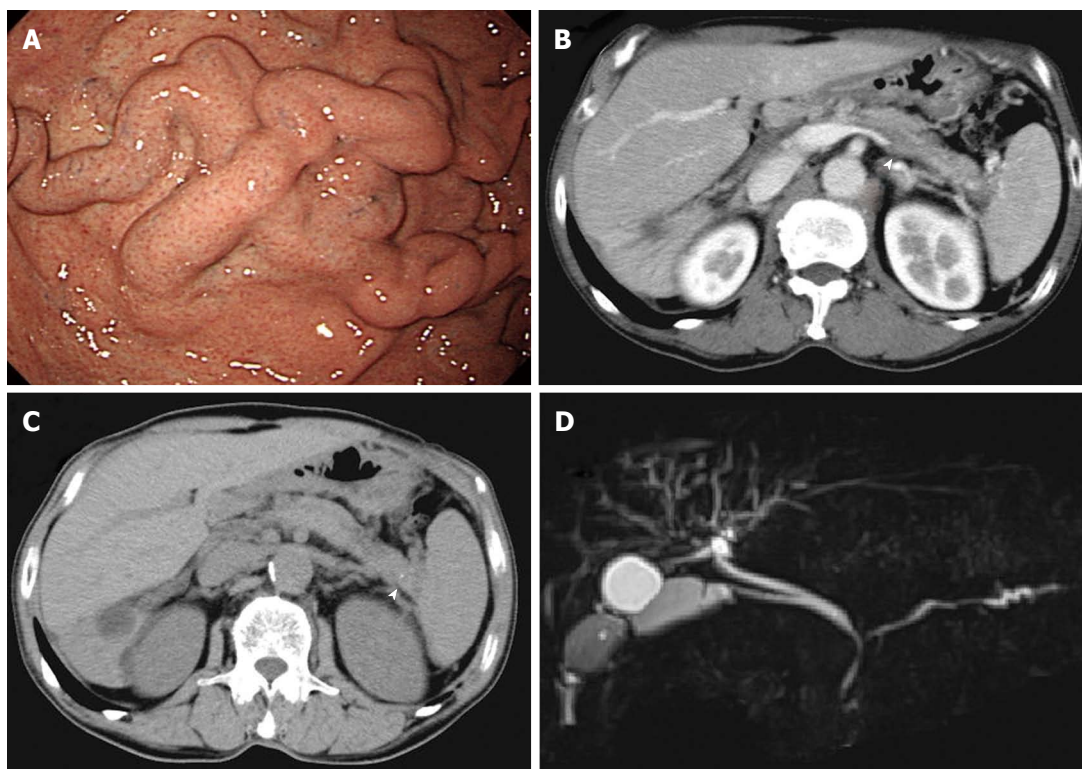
Autoimmune pancreatitis that did not improve with steroid therapy. A: Esophagogastroduodenoscopy showed gastric varices in the fundus of the stomach; B: Computed tomography (CT) showed a slightly enlarged pancreas with a capsule-like rim, an obstructed splenic vein (arrowhead), and splenomegaly; C: CT showed a pancreatic stone in the pancreatic tail (arrowhead); D: Magnetic resonance cholangiopancreatography showed irregular narrowing of the main pancreatic duct in the pancreatic head and body, slight dilation of the main pancreatic duct in the pancreatic tail, stricture of the hilar bile duct and lower bile duct, and dilation of the right intra-hepatic bile duct.
